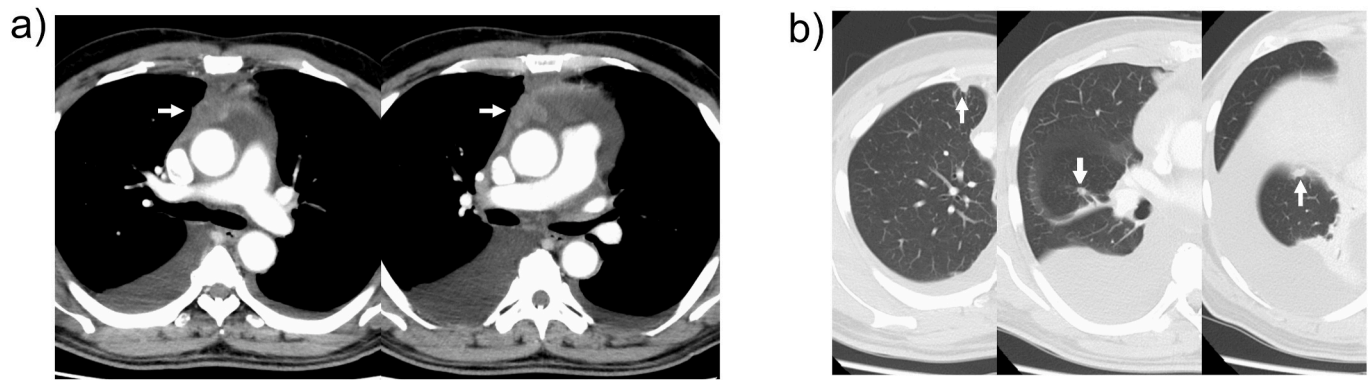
Computed tomographic findings of the anterior mediastinal tumor (A), and pulmonary lesions (B).
